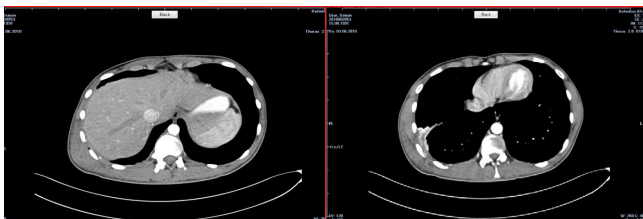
CT image at the initial hospital admission. (a) Mass lesion with irregular contour that suggests chest wall tumor. (b) lower lobe lateral basal segment level atelectasia concurrent image.
